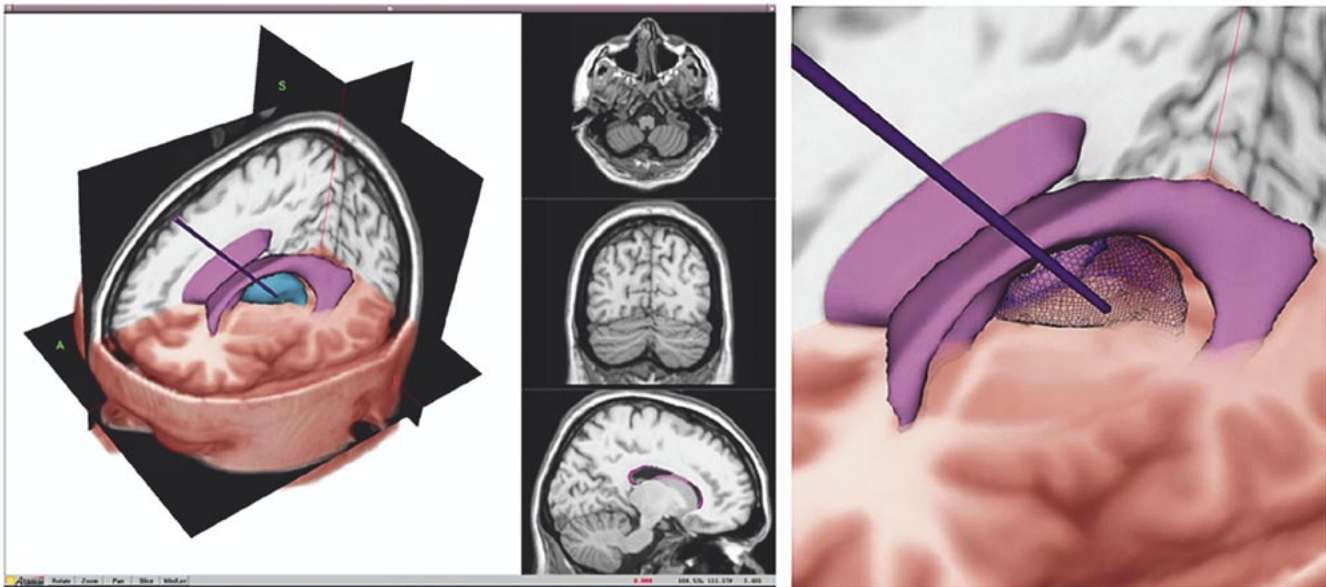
(left) One of many possible display configurations of the ASP visualization platform. Three orthogonal views of a T1-weighted MRI are shown on the right of this image. Larger window displays intersecting orthogonal MRI planes with surface rendered ventricles (purple) and left thalamus (blue). A partial volume rendering of the MR image is simultaneously displayed. An exploratory electrode is shown intersecting the lateral aspect of the thalamus. (right) Magnification of region around the left thalamus, ventricles, and modeled electrode. Thalamus displayed as a triangulated mesh.
